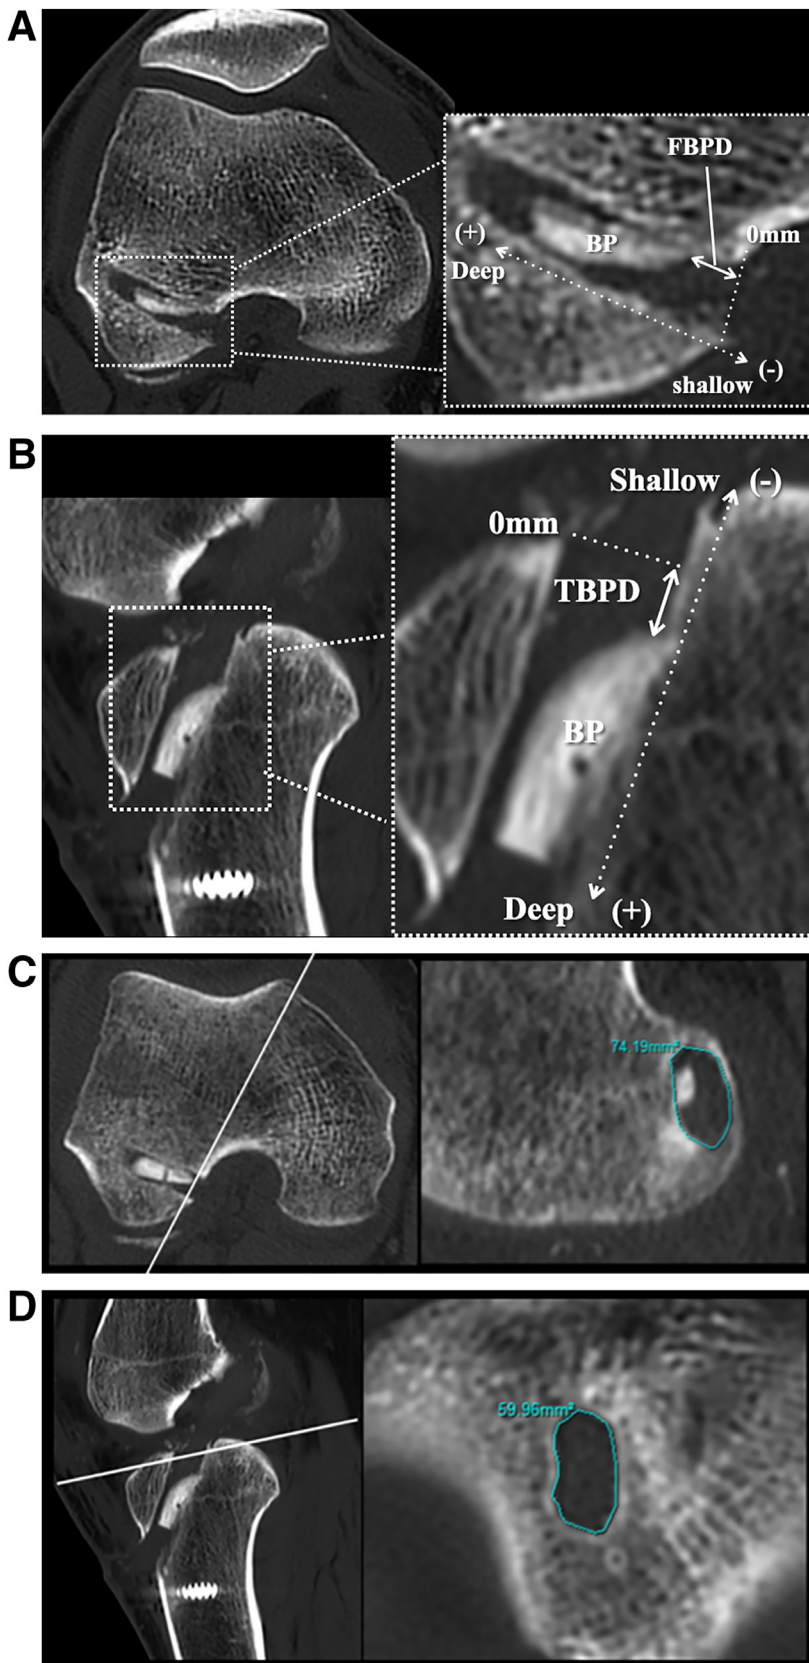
Measurements of femoral and tibial bone plug depth, bone plug length, and tunnel area on computed tomography of the right knee. (A) Femoral bone plug depth (FBPD) was defined as the distance from the distal end of the femoral bone plug (BP) to the tunnel aperture. (B) Tibial bone plug depth (TBPD) was defined as the distance from the proximal end of the tibial bone plug (BP) to the tunnel aperture. (C) Sagittal reconstruction was performed at a level parallel to the outer rim of the lateral femoral condyle. The contour of the femoral tunnel wall was traced on the slice 2 mm deep to the aperture to measure its cross-sectional area. (D) Axial reconstruction was performed at a level parallel to the outer rim of the intercondylar fossa of the tibia. The contour of the tibial tunnel wall was traced on the slice 2 mm deep to the aperture to measure its cross-sectional area.
